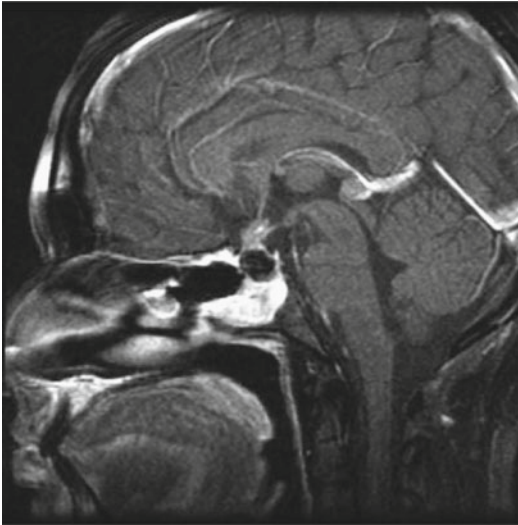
A sagittal T1-weighted MR image following contrast administration shows an anterior third ventricle mass and a pineal region mass that both enhance relative to the normal brain. After biopsy, this tumor was diagnosed as a germinoma
